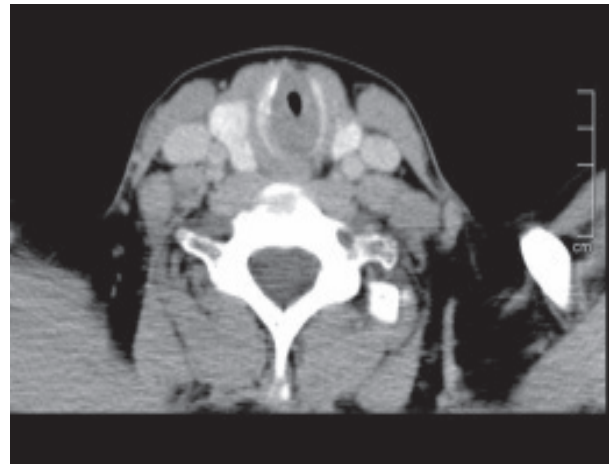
CT Scan of the Neck Showing Subglottic Stenosis
